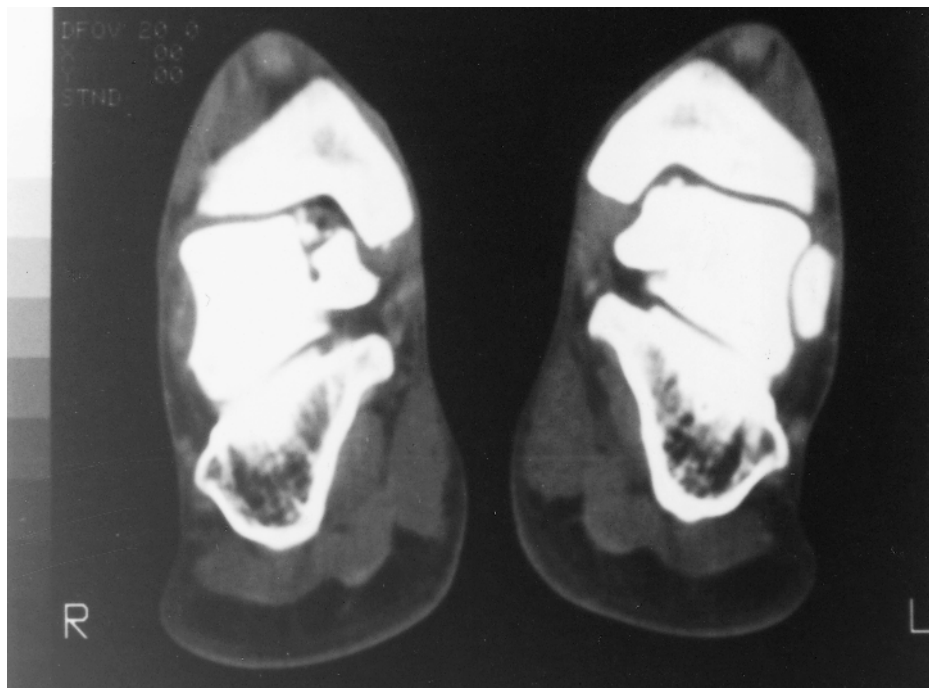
Same lesion as in Figure 7.71 demonstrated by a computed tomography (CT) scan. This technique is reported to be superior to the tomogram for showing the location and extent of the lesion for preoperative planning.
